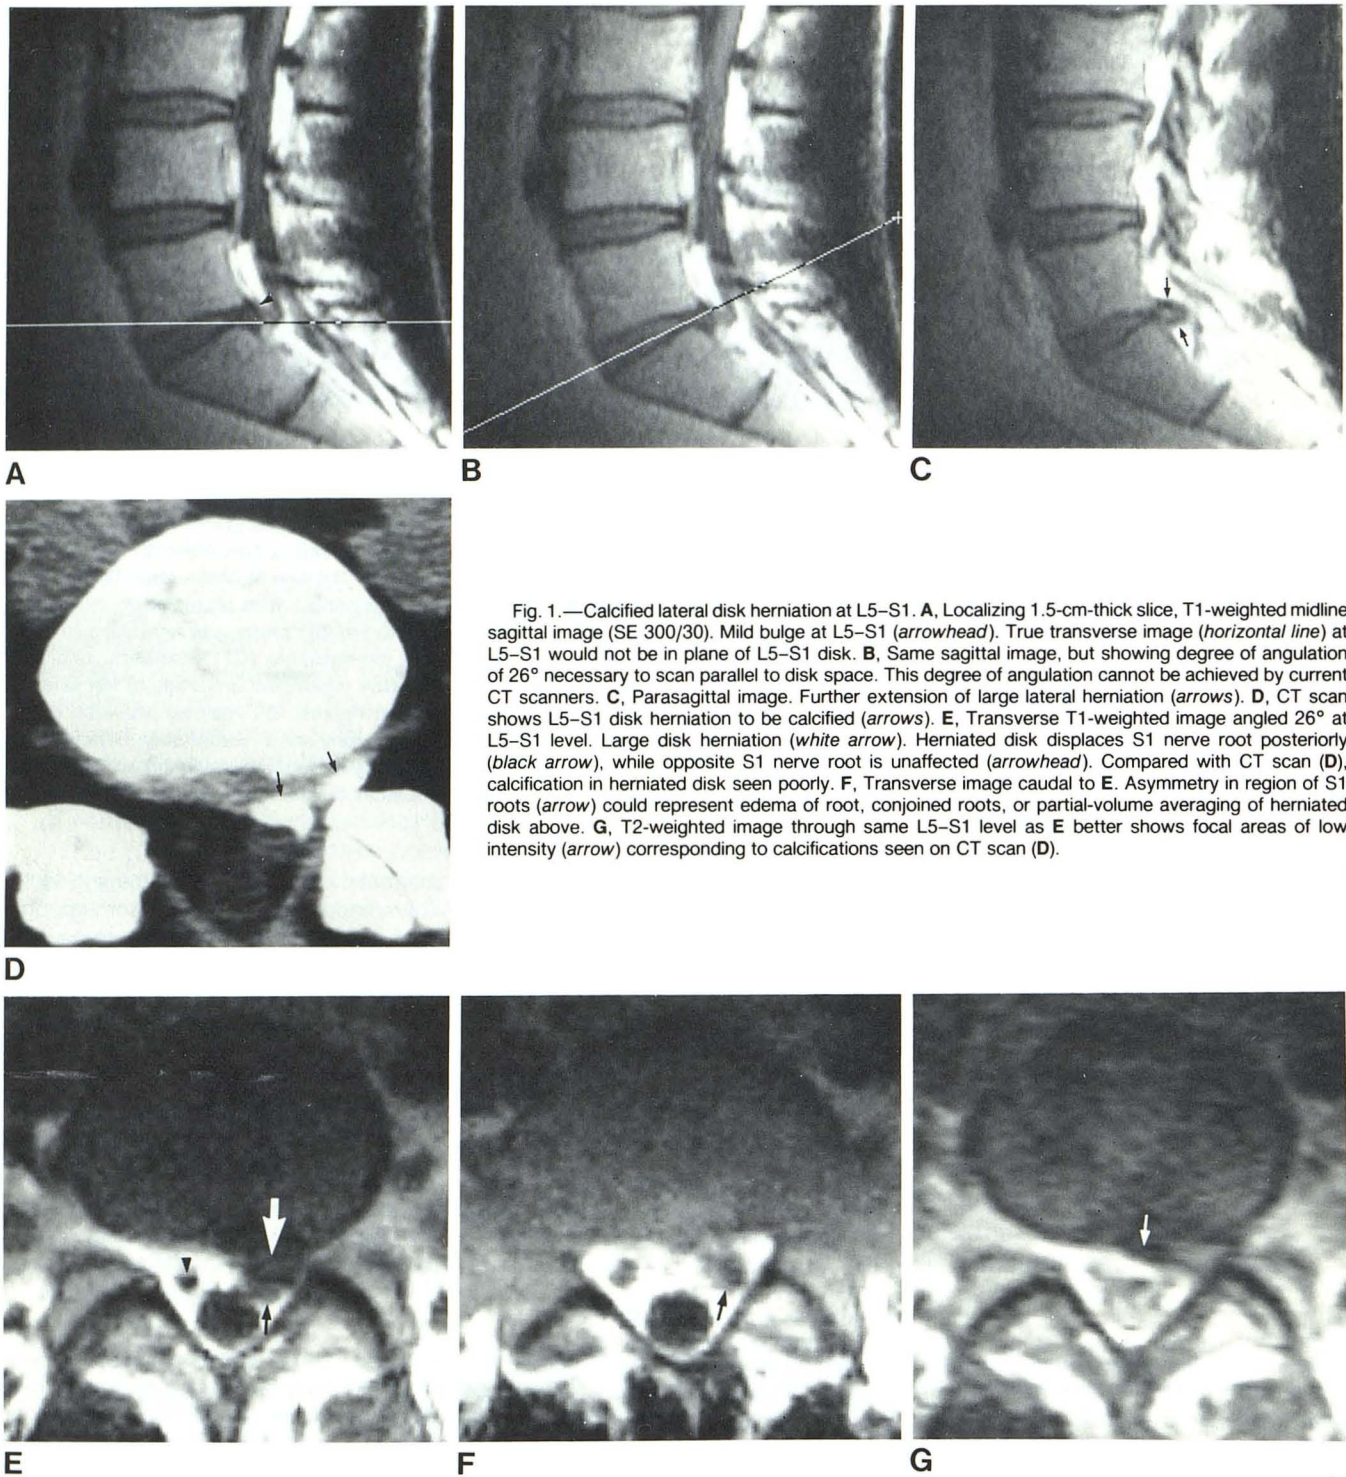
Calcified lateral disk herniation at L5–S1. A, Localizing 1.5-cm-thick slice, T1-weighted midline sagittal image (SE 300/30). Mild bulge at L5–S1 (*arrowhead*). True transverse image (*horizontal line*) at L5–S1 would not be in plane of L5–S1 disk. B, Same sagittal image, but showing degree of angulation of 26° necessary to scan parallel to disk space. This degree of angulation cannot be achieved by current CT scanners. C, Parasagittal image. Further extension of large lateral herniation (*arrows*). D, CT scan shows L5–S1 disk herniation to be calcified (*arrows*). E, Transverse T1-weighted image angled 26° at L5–S1 level. Large disk herniation (*white arrow*). Herniated disk displaces S1 nerve root posteriorly (*black arrow*), while opposite S1 nerve root is unaffected (*arrowhead*). Compared with CT scan (D), calcification in herniated disk seen poorly. F, Transverse image caudal to E. Asymmetry in region of S1 roots (*arrow*) could represent edema of root, conjoined roots, or partial-volume averaging of herniated disk above. G, T2-weighted image through same L5–S1 level as E better shows focal areas of low intensity (*arrow*) corresponding to calcifications seen on CT scan (D).
